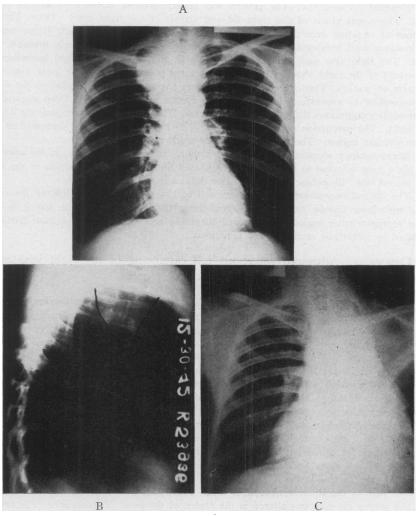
(A and B) Case 4: Routine PA and lateral roentgenograms of chest showing an apical tumor. Note the triangular area of atelectasis in the lateral film.
